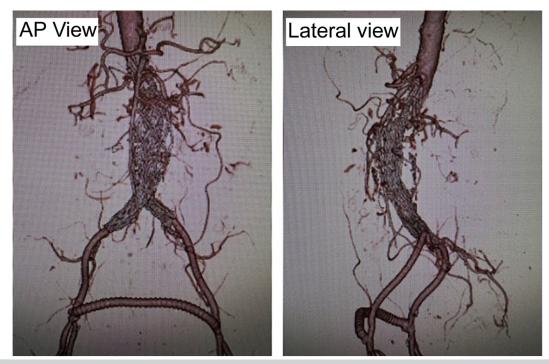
Postoperative three-dimensional computed tomography image of patient 1 after repeat endovascular aortic repair (EVAR). *AP*, Anteroposterior.
